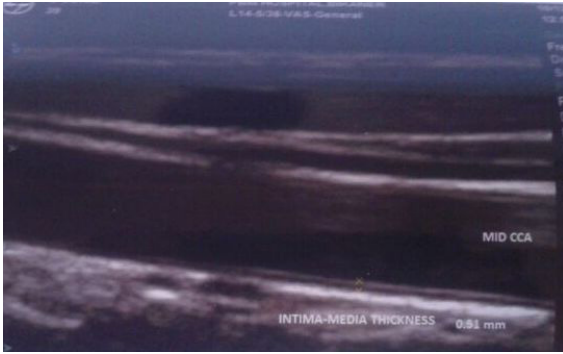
Longitudinal ultrasound image of the CCA in a control case. The intima-medial thickness (0.51 mm) is depicted by electronic calipers. The near caliper shows the intima-lumen interface and the far caliper shows the media-adventitia interface
